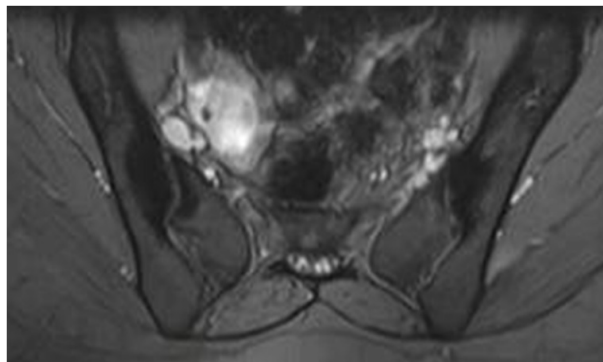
Sacroiliac MRI showing bilaterally sacroiliitis
